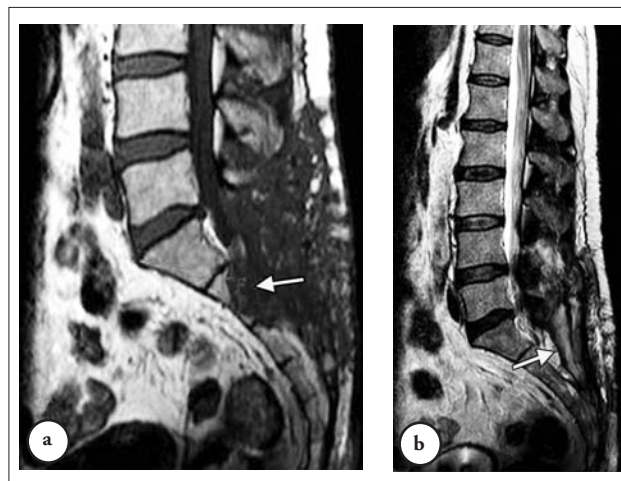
Patient MRI a) T1-weighted and b) T2-weighted sagittal images of the lumbosacral spine show a roundish intracanal mass opposite S2 and S3 (arrows). The axial c) and sagittal d) T1-weighted images show that the mass is well defined with intense enhancement (arrows).
